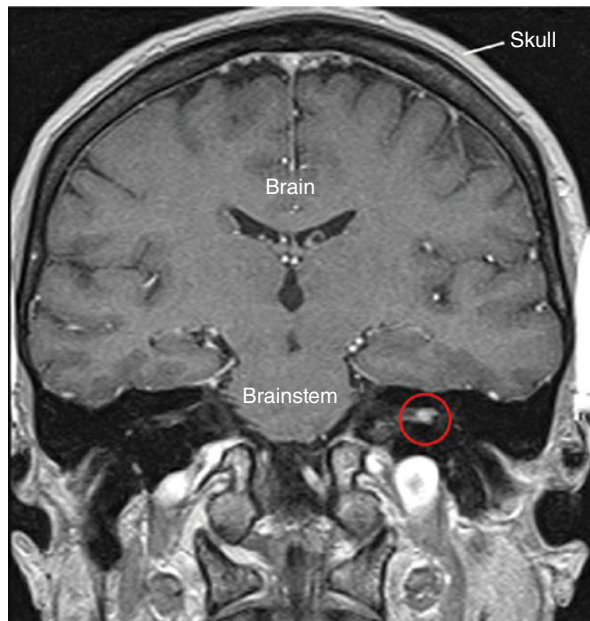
A coronal MRI image of a patient with a left acoustic neuroma (vestibular schwannoma) (circled). Courtesy of Dr. Edward Weber.
